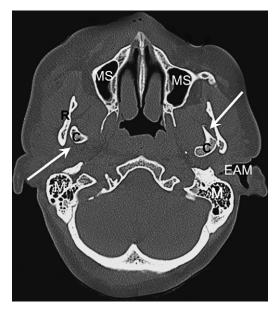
Axial CT scan in bone windows. White arrows indicate bilateral condyle fractures with anteromedial dislocation. C, condyle; EAM, external auditory meatus; M, mastoid air cells; MS, maxillary sinus; R, ramus.
